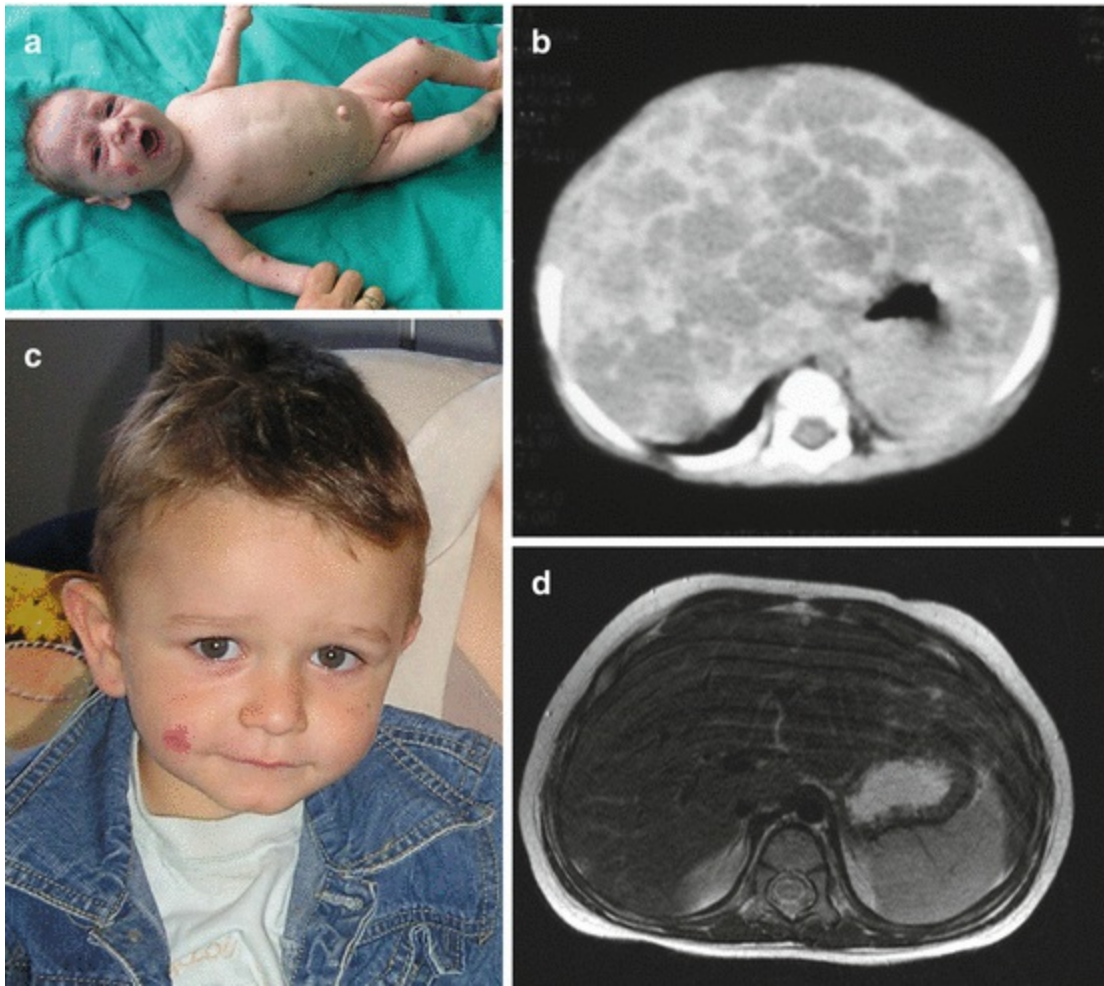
Diffuse neonatal hemangiomatosis, treatment with cyclophosphamide: (a) before the treatment initiation; (b) computerized tomography revealed multiple hepatic hemangiomas; (c) after the treatment; (d) magnetic resonance imaging revealed no presence of hepatic hemangioma
